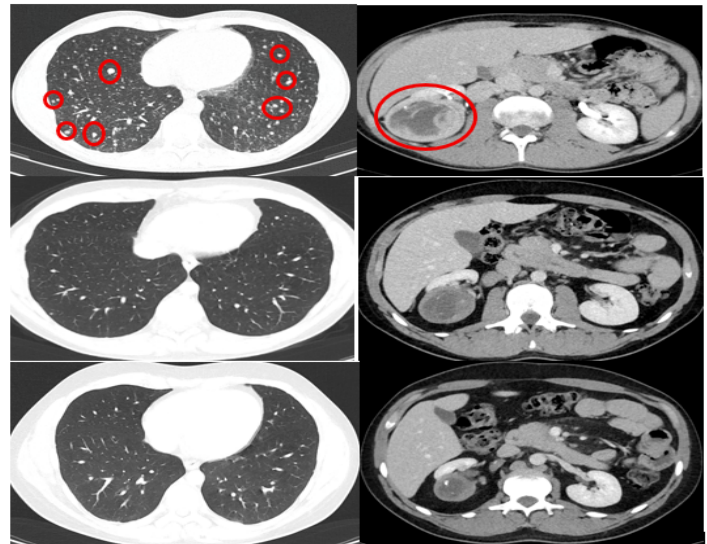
Initial CT scan in December 2023 and following CT's in April and September 2024.
